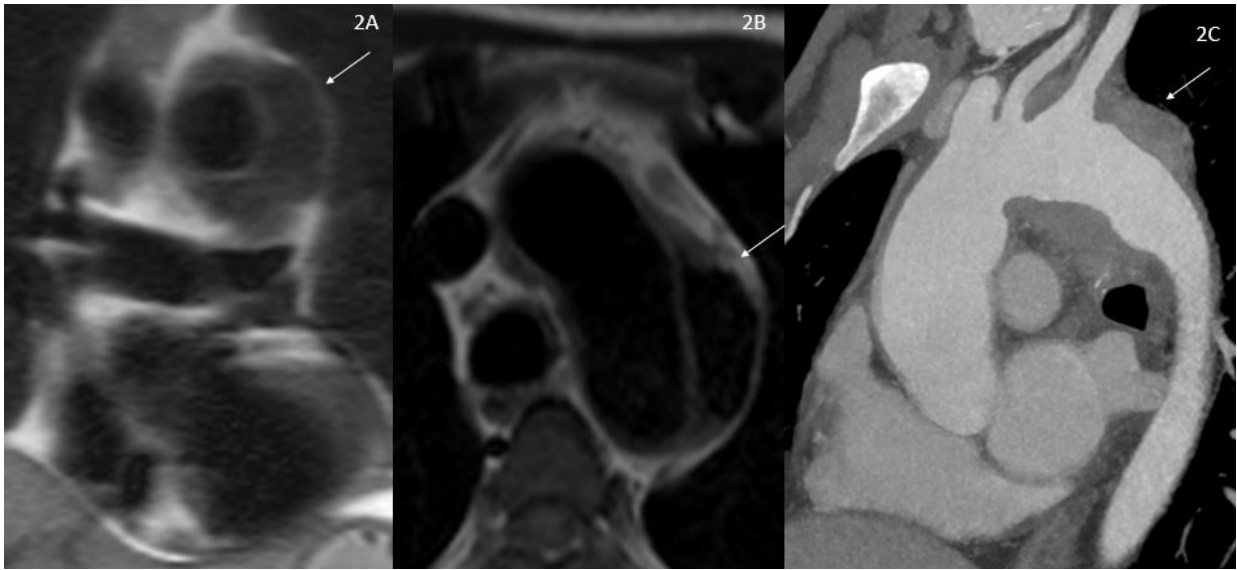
Case 1. A, B) Coronal and axial T1W MRI showing hypointense lesion (shown by white arrow) surrounding the aortic arch. C) Sagittal computed tomography image showing soft tissue lesion (indicated by white arrow) surrounding the distal arch and proximal descending thoracic aorta
